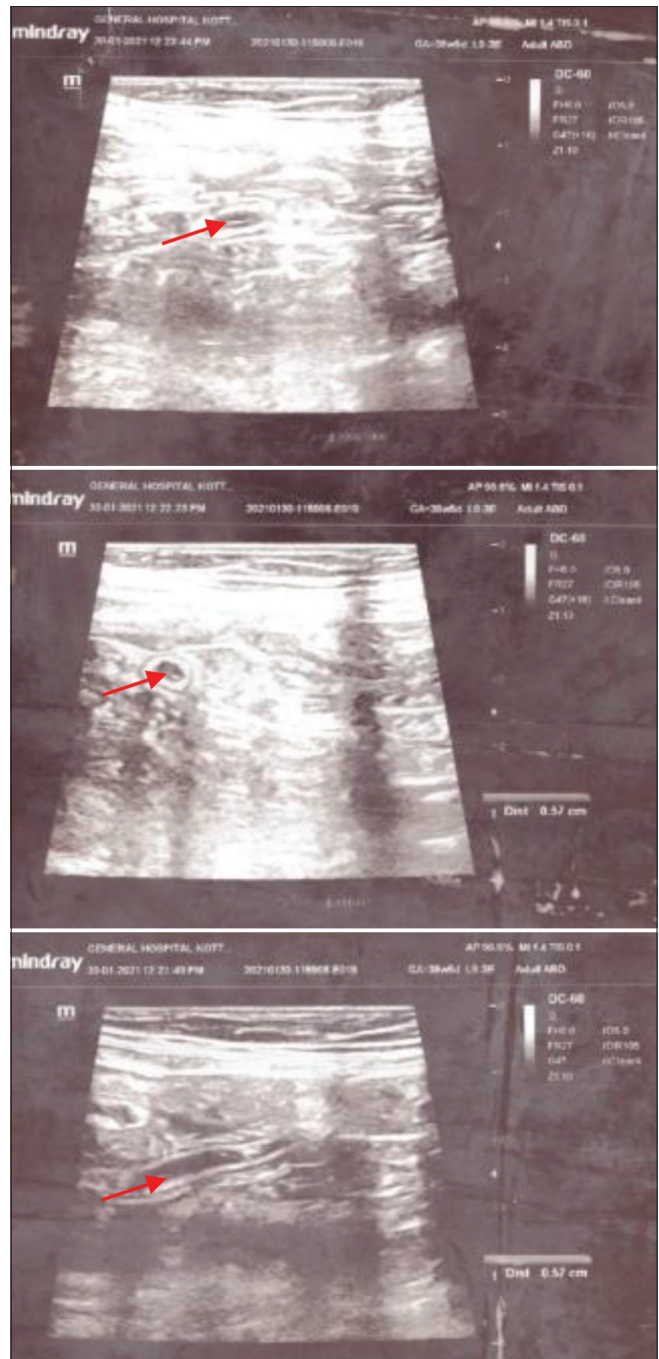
Ultrasonography showing prominent appendix before treatment
